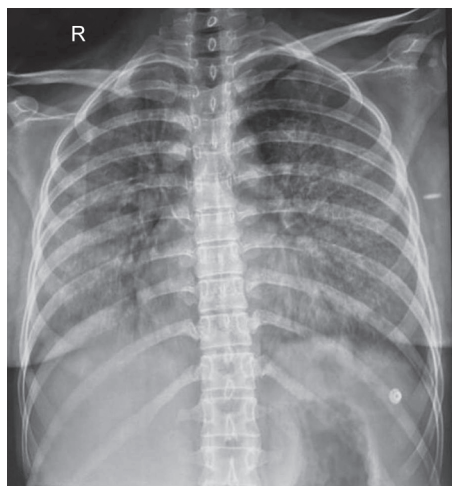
Chest X-ray suggestive of COVID-19 pneumonia
